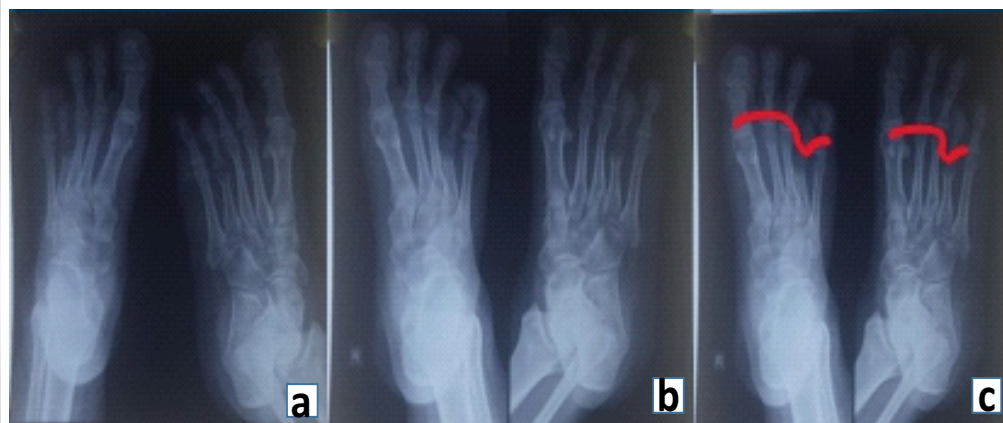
Pre-operative X-ray. (a) Anterior posterior and oblique view of left foot with short 4th metatarsal and fourth proximal phalanx. (b) Anterior posterior and oblique view of the right foot with a short 4th metatarsal and fourth proximal phalanx. (c) Parabola not maintained.
